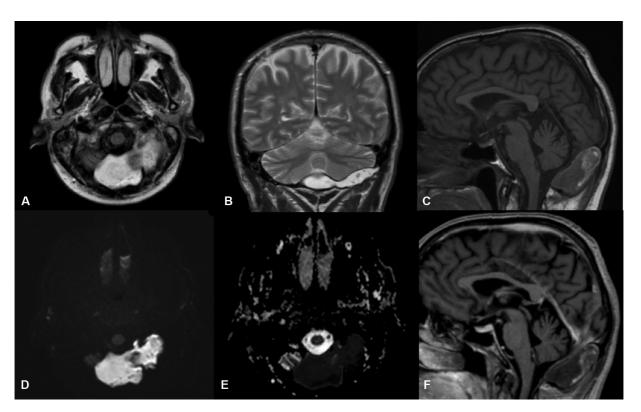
Brain magnetic resonance imaging A. Axial FLAIR sequence; B. Coronal T2 weighted sequence; C. Saqittal T1 weighted sequence; D. DWI; E. ADC map. F. Saqittal T1 contrast enhanced weighted sequence showing the well-delimited intradiploic lesion in the posterior fossa, with intracranial extradural extension molding the cerebellar parenchyma. The lesion presents T2/FLAIR hyperintensity (images A and B), heterogeneous signal on T1, mostly hypointense with small areas of hyperintensity arrow head (image C), and no contrast enhancement (image F). Finally, note the characteristic restricted diffusion pattern (images D and E). This is an intradiploic epidermoid cyst.
